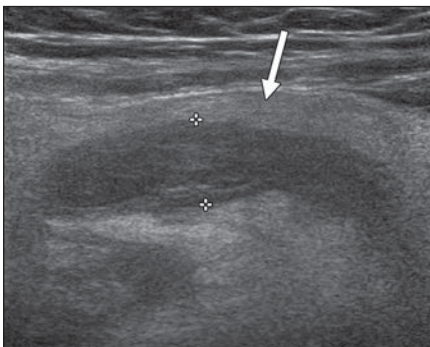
4-year-old boy with abdominal pain. Transverse ultrasound image of right lower quadrant obtained with linear transducer shows 4-mm normal appendix that drapes over iliac artery and vein.
